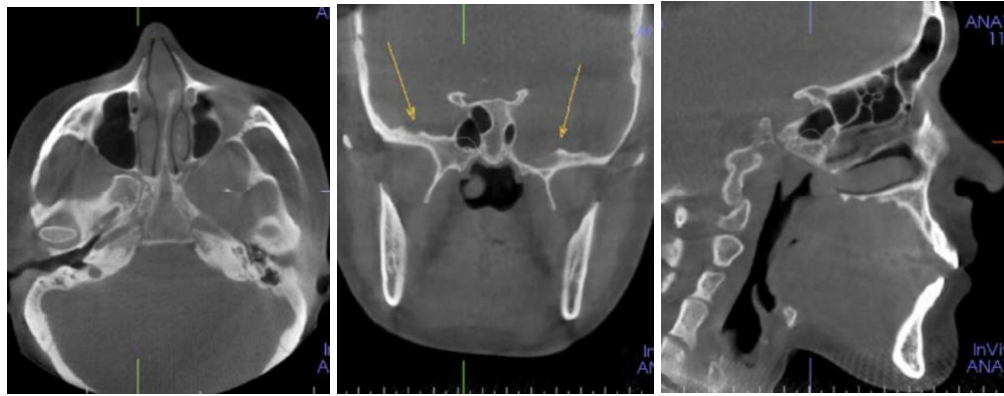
Axial (left), coronal (middle), and sagittal (right) CBCT cross-sections demonstrating asymmetric skull base. There is thinning and expansion of the greater wing of the sphenoid bone. The orbital surface of the greater wing of the sphenoid is expanded.
